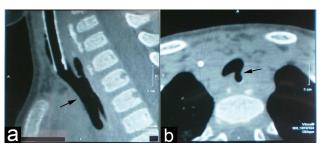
Computed tomography (CT) findings after pulling upwards endotracheal tube, sagittal (a) and axial plane (b) (TEF – black arrow).
